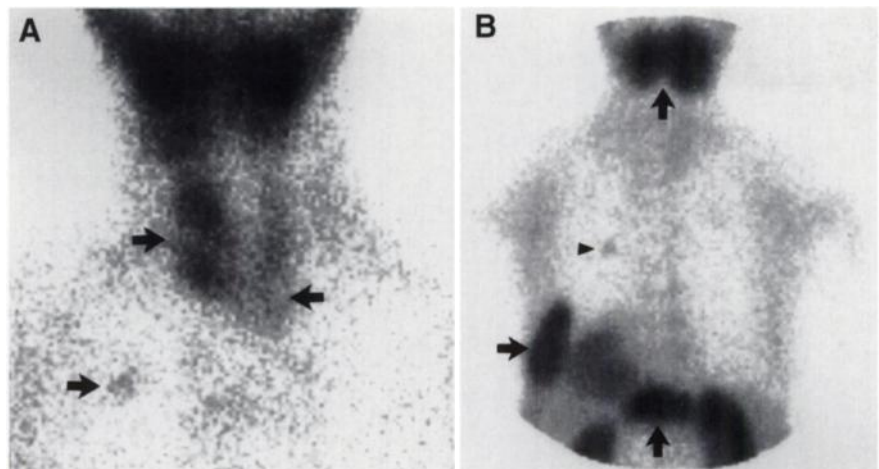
Technetium-99m-tetrofosmin scintigraphy. (A) Anterior view shows no significant uptake in the thyroid nodules (arrows), but there is a focus of abnormal uptake in the upper right hemithorax (arrow). (B) Chest and abdomen posterior view shows abnormal uptake in cervical and dorsal spine and in the left hemithorax (arrows). There is normal tracer distribution in the myocardium, superior pole of the kidneys.
